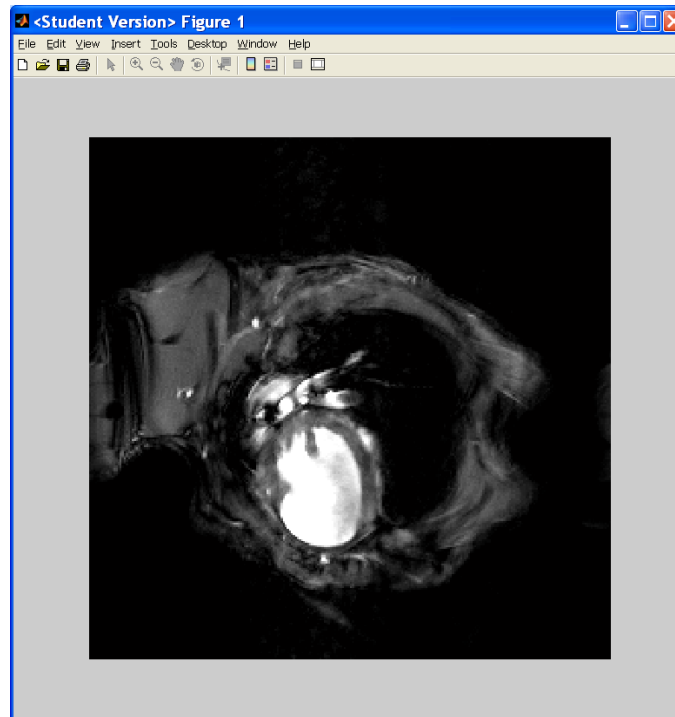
An image displayed after MRI raw data is imported into the program.
